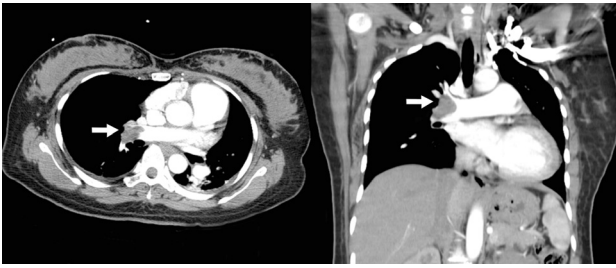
Heart aorta pulmonary enhanced computed tomography showed filling defect in the pulmonary arteries of the right middle lobe. Arrow indicated a pulmonary thromboembolism.
